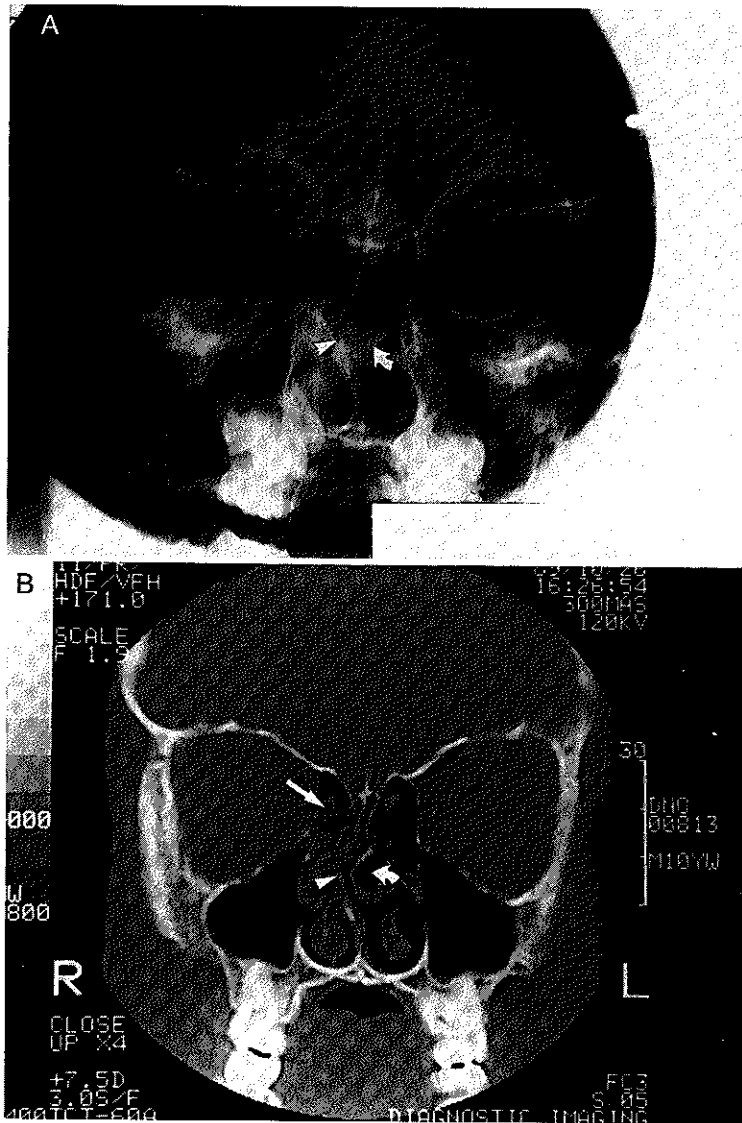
A, plain x-ray film of the sinuses (Caldwell view) showing right septal deviation (*arrowhead*) and a left concha bullosa (*curved arrow*), but no sinus disease is apparent. B, coronal CT of the sinuses of the same patient in A showing right ethmoid mucosal thickening (*arrow*), right septal deviation (*arrowhead*), and left concha bullosa (*curved arrow*).
